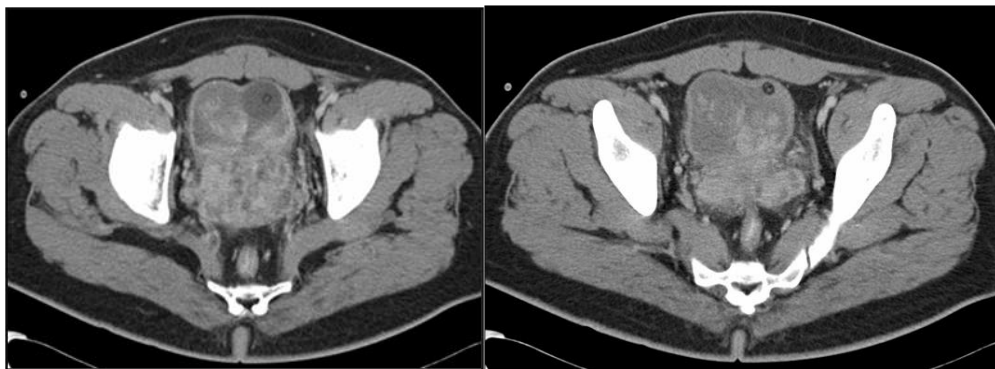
Attached are the axial views of CT TAP for patients with locally advanced prostatic sarcoma infiltrating into and seminal vesicles with bladder clots.
